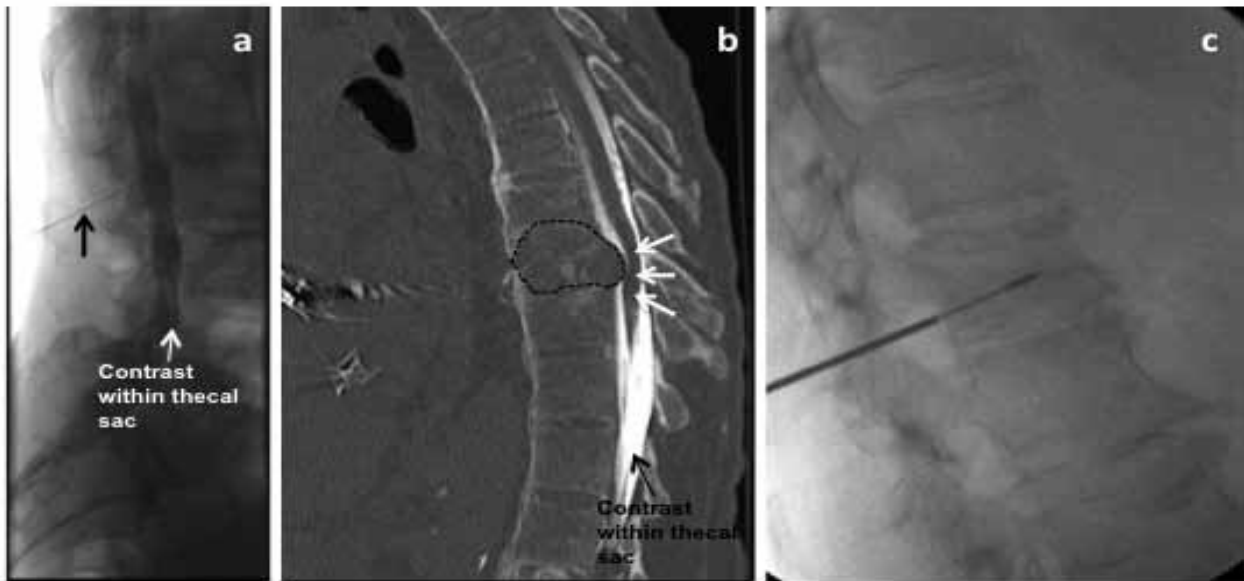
CT myelography and vertebral biopsy. (a) Lateral fluoroscopic image shows contrast injected into thecal sac using 22-gauge spinal needle (black arrow) at the L1/2 level. (b) CT lateral image post intrathecal contrast injection shows posterior displacement of the conus (white arrows) by a discitis related abscess (black dashed lines). (c) Biopsy needle was advanced into vertebral body under fluoroscopic guidance, ensuring a diagnostic sample is obtained safely.
